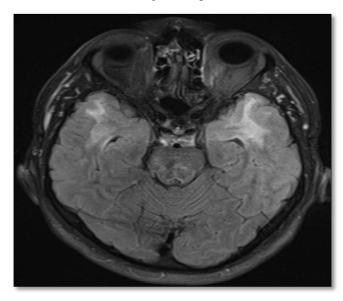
MRI of the brain (axial section through temporal poles FLAIR).
